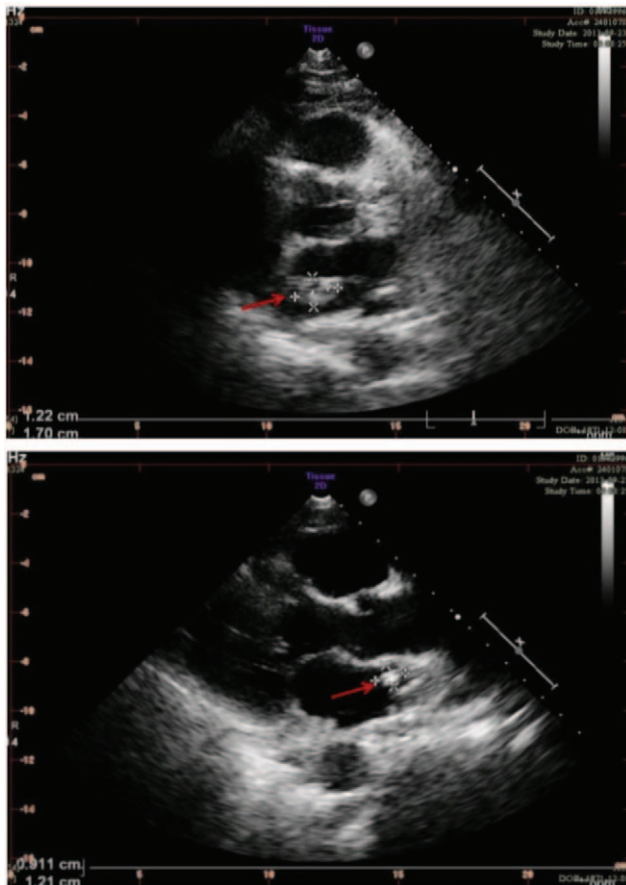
Echocardiography revealed 2 masses in the left atrium (approximately 1.0 and 0.9 cm in diameter).
